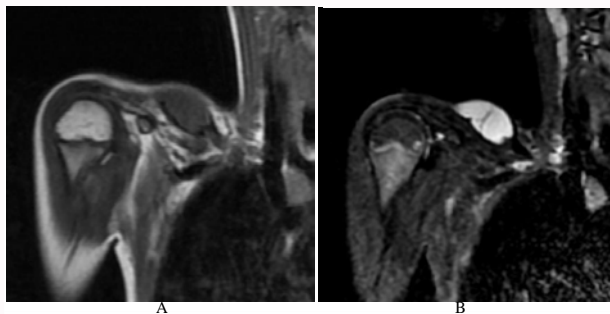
(A) On T1-weighted coronal MR image, the lesion is observed in homogeneous hypointense signal. (B) T2-weighted fat-suppressed coronal MR image shows a homogeneous hyperintense internal structure, except for a thin septation within the lesion.
